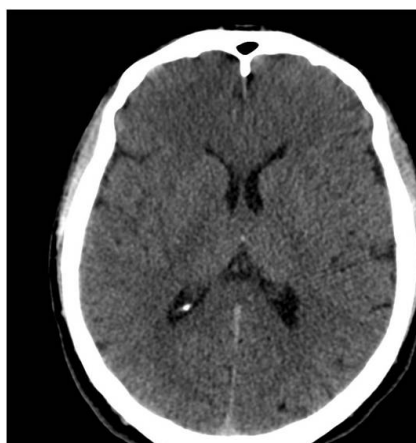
Patient's first nonenhanced CT was normal when he was presented to the emergency service.
